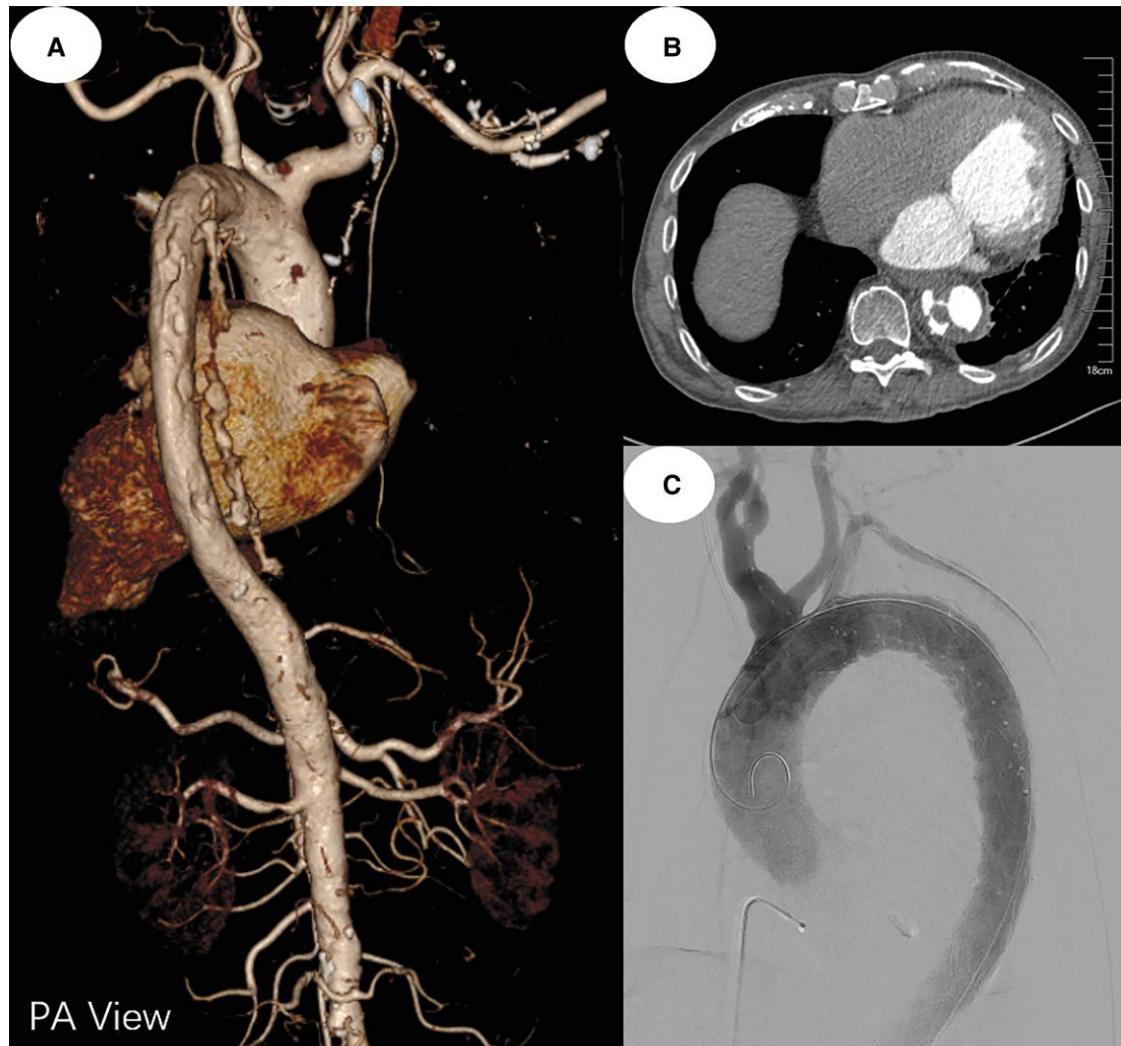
Computed tomography angiography after MitraClip implantation revealed an acute type B aortic dissection (A and B); the dissection extends from the thoracic aorta to the upper abdominal aorta, with a rupture visible in the descending aorta, just at the mid-oesophageal level (A and B); X-ray showed no exsmosis of contrast media after endovascular stenting treatment and the dissection disappeared (C).
